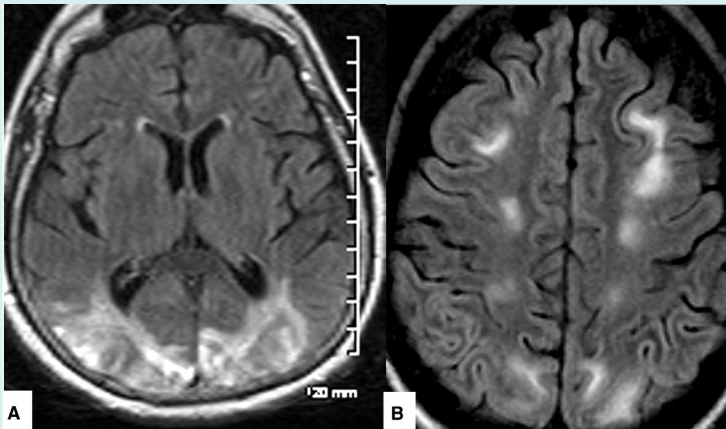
MRI showing common findings in PRES: (a) classic parietal-occipital pattern; (b) superior frontal sulcus pattern.<sup>1</sup>
